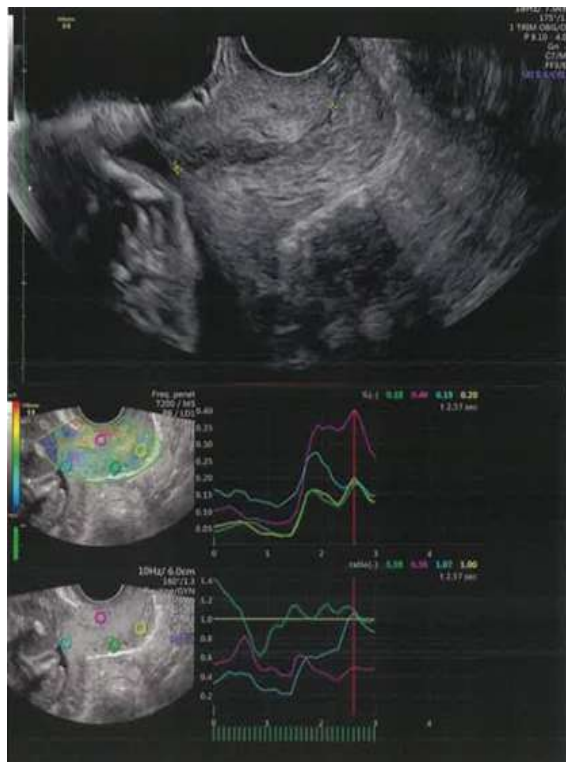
Transvaginal Ultrasound Scan Grey scale and Elastography image of cervix in mid-sagittal view. ROI: Endocervical canal at internal Os (blue circle), Anterior and Posterior lip at mid part of cervix (pink, green circles) Reference region: Posterior lip of cervix at external Os (yellow circle)
